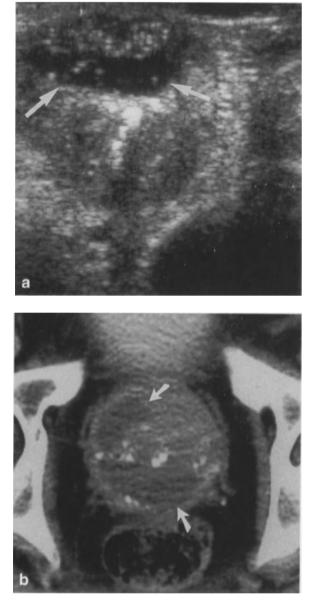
a,b. Prostatic abscess. a Transrectal ultrasound demonstrating cystic mass involving the right seminal vesicle and prostate (*white arrows*). Calcifications with posterior shadowing are incidentally present. b CT showing low density prostatic mass (*white arrows*). At surgery, a large abscess involving the prostate and right seminal vesicle was unroofed
